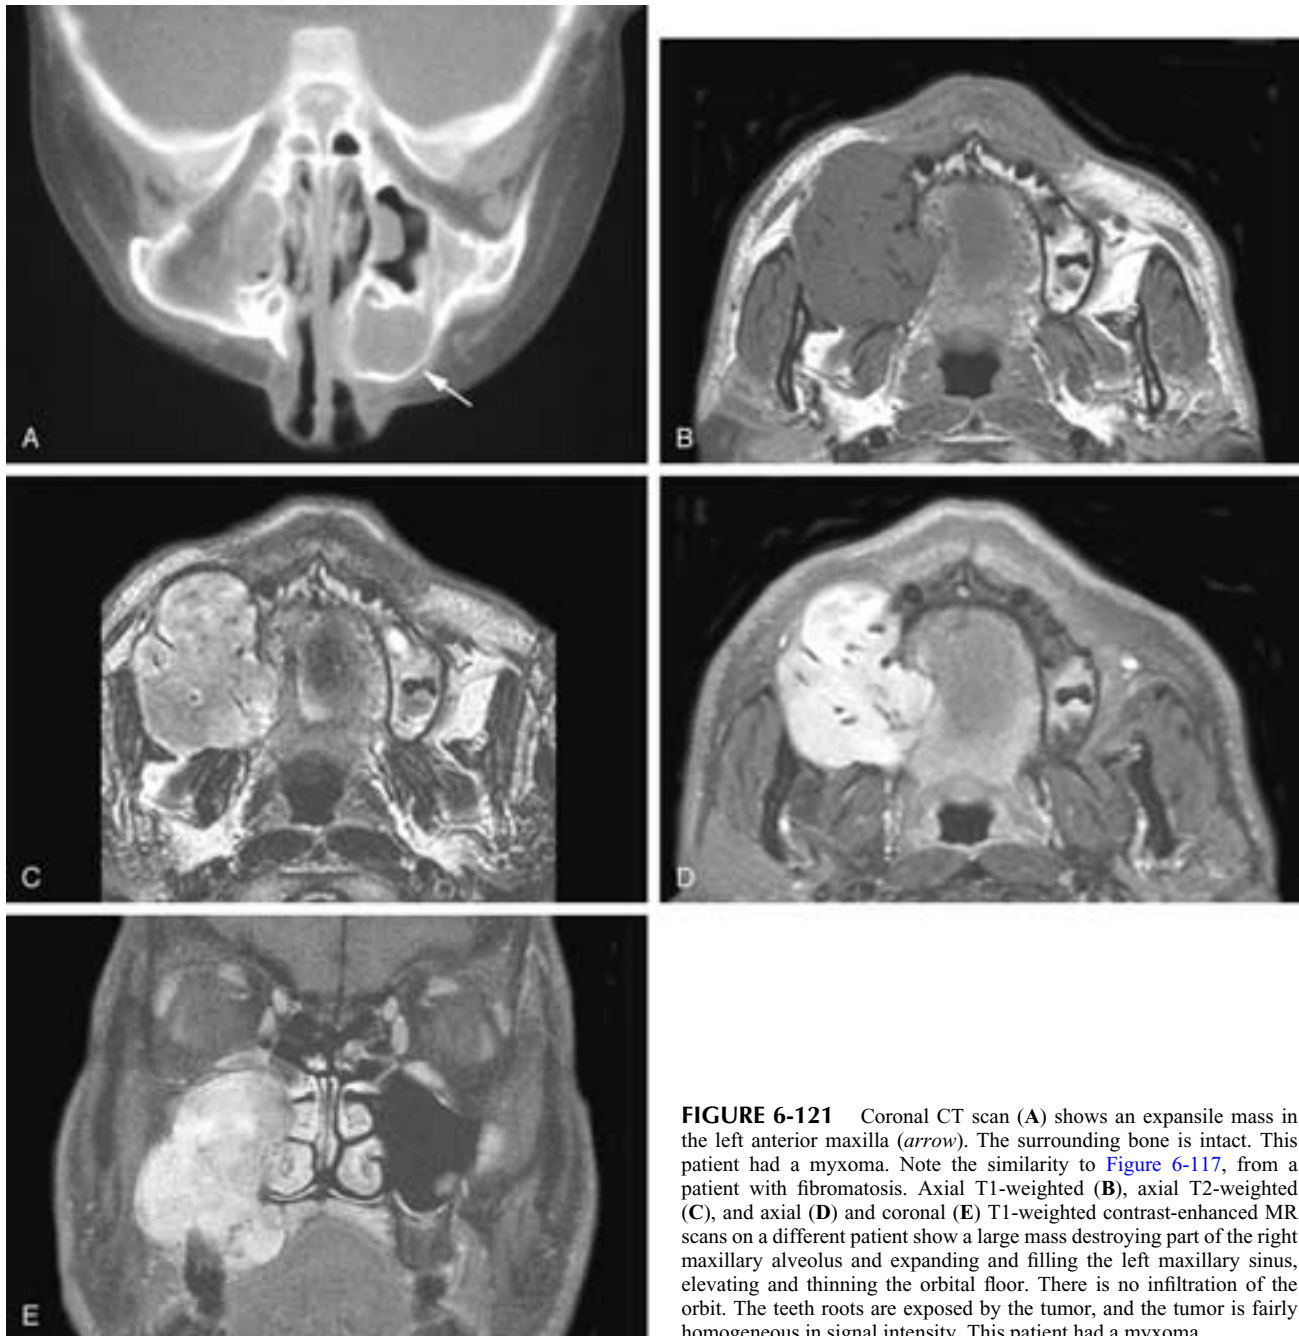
Coronal CT scan (A) shows an expansile mass in the left anterior maxilla (*arrow*). The surrounding bone is intact. This patient had a myxoma. Note the similarity to [Figure 6-117](#), from a patient with fibromatosis. Axial T1-weighted (B), axial T2-weighted (C), and axial (D) and coronal (E) T1-weighted contrast-enhanced MR scans on a different patient show a large mass destroying part of the right maxillary alveolus and expanding and filling the left maxillary sinus, elevating and thinning the orbital floor. There is no infiltration of the orbit. The teeth roots are exposed by the tumor, and the tumor is fairly homogeneous in signal intensity. This patient had a myxoma.
